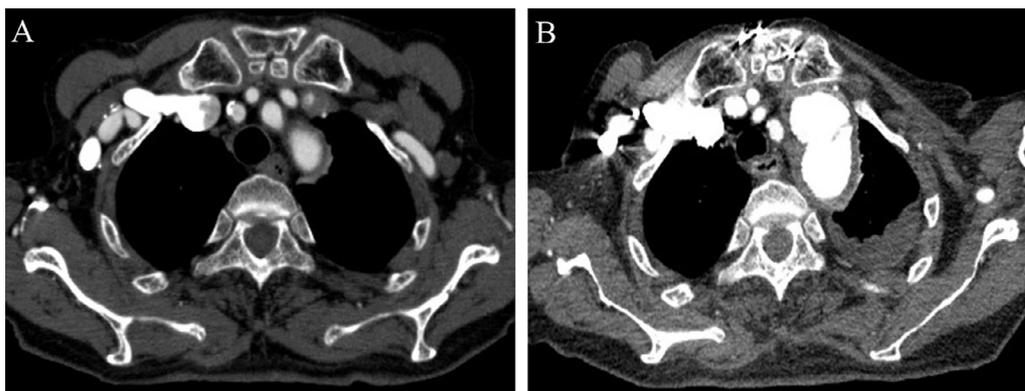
Computed tomographic images from case 2 (A) before and (B) 32 months after surgery. Remarkable pectoral muscle atrophy that had occurred on both sides is evident in panel B. This patient underwent a total arch replacement for an ascending and arch aneurysm that was 70-mm wide at its maximum diameter. At 32 months after surgery, the remnant graft of the left axillary artery was removed, because the prosthetic graft was infected.
